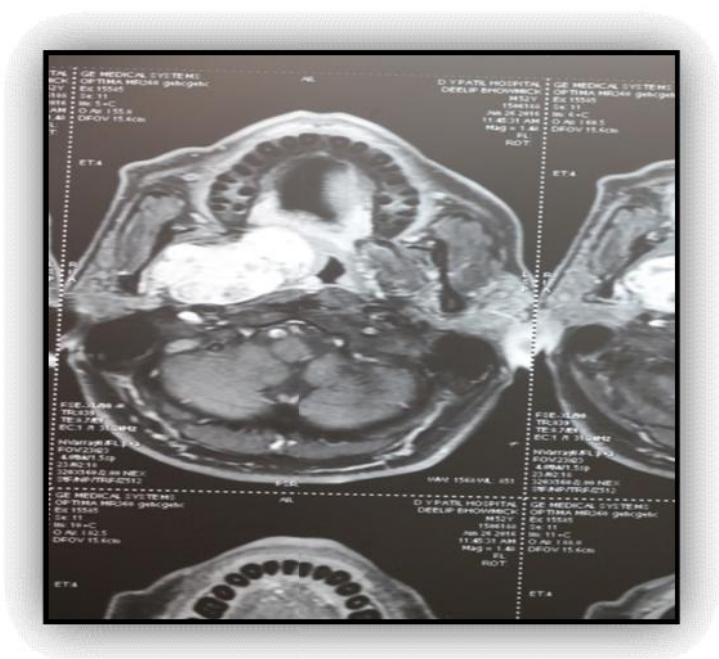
MR image of tumor.
